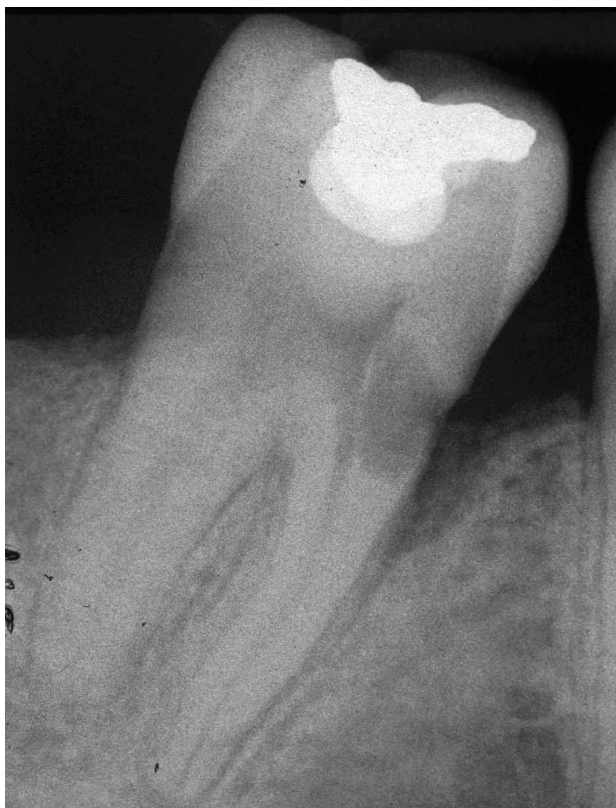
Radiographic appearance of sub-epithelial external root resorption. Note the small opening and the ballooning of the defect inside the root. The pulp is not penetrated. Bone resorption similar to an angular bony defect is seen.
